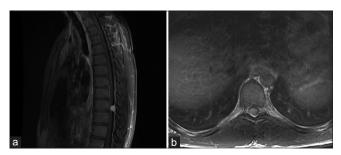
(a and b) Sagittal (left) and axial (right) T1-weighted gadolinium-enhanced magnetic resonance imaging of the thoracic spine reveal an intradural extramedullary homogeneously enhancing mass at the T10-11 level compressing the spinal cord.
